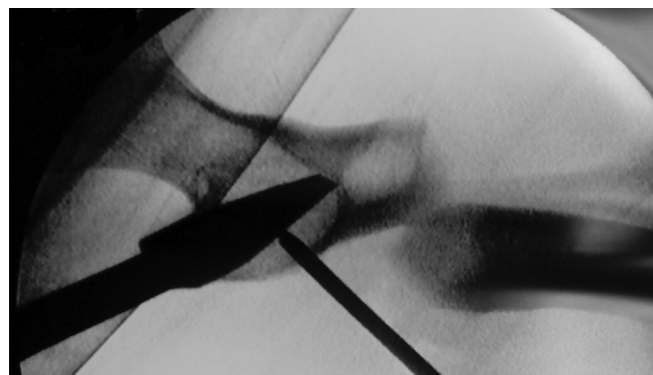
Intraoperative X-ray showing complete obliteration of proximal intra-medullary cavity.
